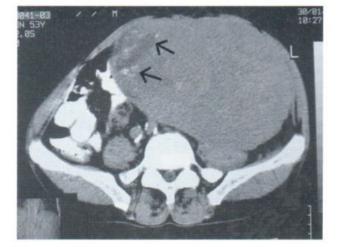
CT scan obtained before I.V. contrast administration showed a large soft tissue tumor in left-sided retroperitoneum with small calcifications and hypodense areas (arrows).
